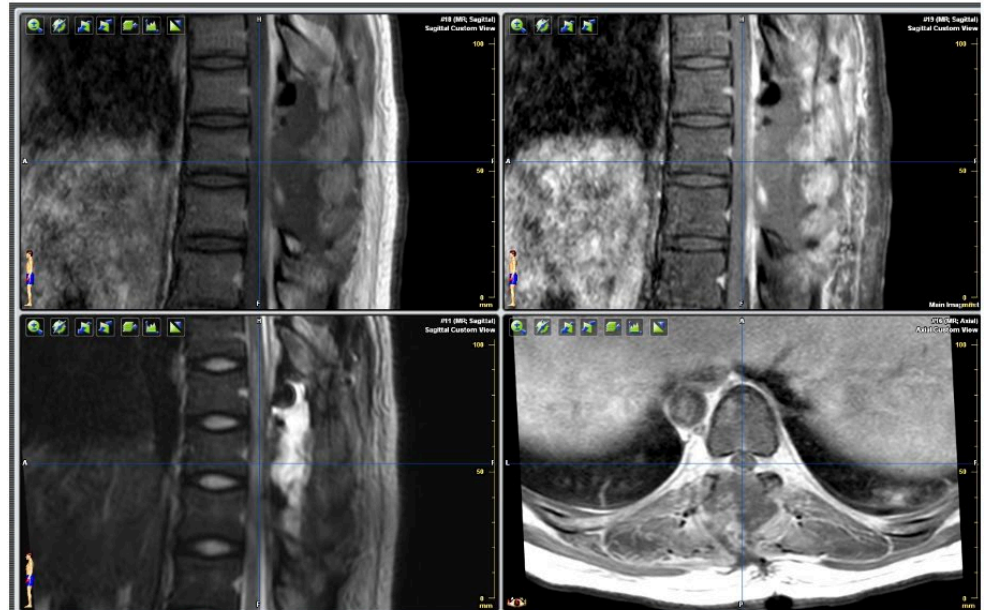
MRI spine on post operation day 2, showing no residual enhancement lesion
